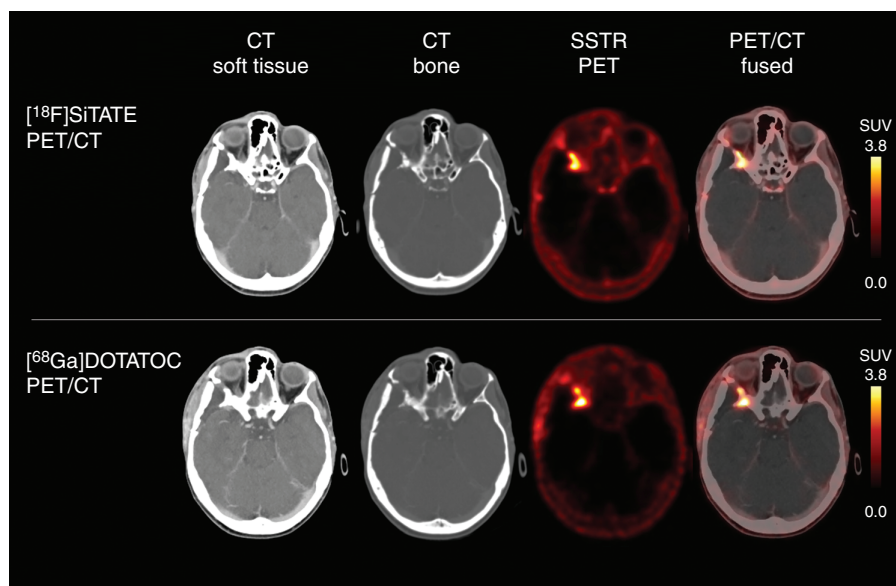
¹⁸F-SiTATE (top row) and ⁶⁸Ga-DOTATATE PET/CT (bottom row) of a patient after resection of a WHO grade I sphenoid wing meningioma show residual tumor laterally located to the right orbit. Visually, tumoral uptake on ¹⁸F-SiTATE was highly comparable to ⁶⁸Ga-DOTATATE PET/CT. Note the lower spatial resolution of the ⁶⁸Ga-labeled peptide DOTATATE compared to ¹⁸F-SiTATE PET.
